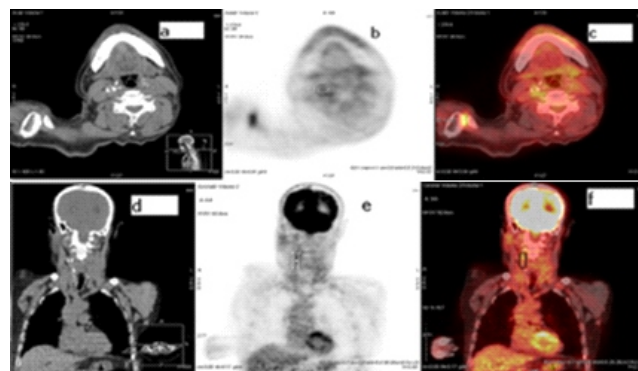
Fluorine-18-FDG-PET/CT: typical focal ^{18}F -FDG uptake in right carotid vessel, suggestive of active carotid plaque [31].
